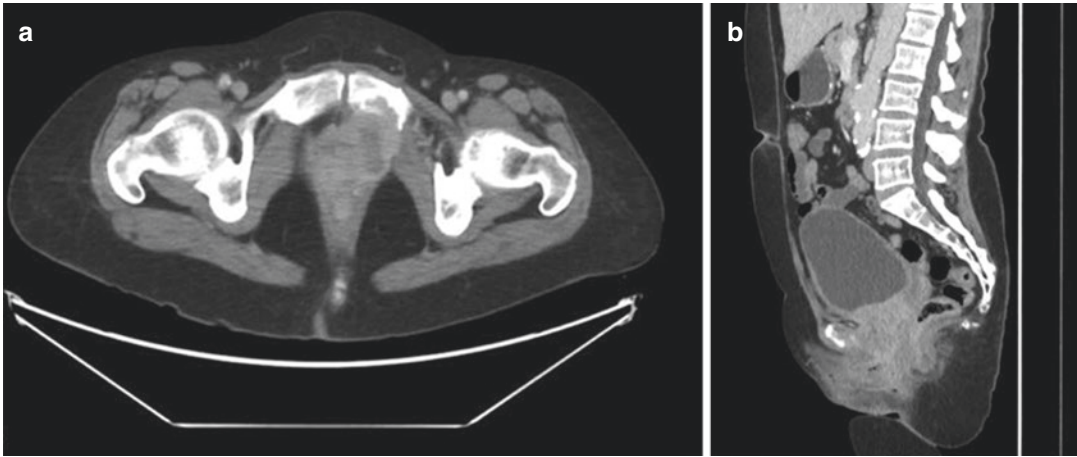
Contrast CT images of urethral carcinoma. (a) Axial view of infiltrative enhancing mass measuring $5.8 \times 5.7 \times 6.6$ cm with invasion into the left pubic bone.
